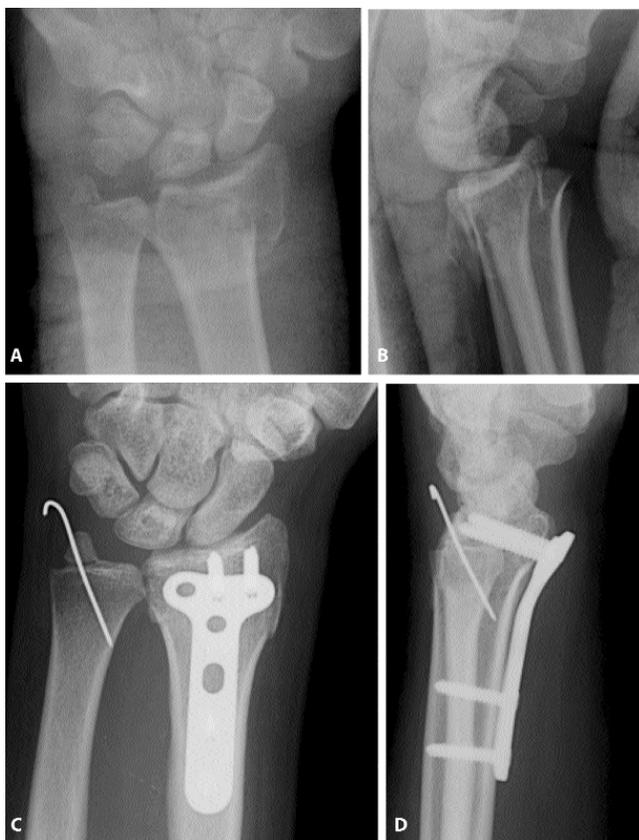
Anteroposterior (AP) (2-A) and lateral (2-B) X-rays of a 45-year-old male with left distal radius fracture secondary to road traffic accident (RTA). At two-month follow-up, AP (2-C) and lateral (2-D) X-rays showed union and maintenance of radiological parameters.
